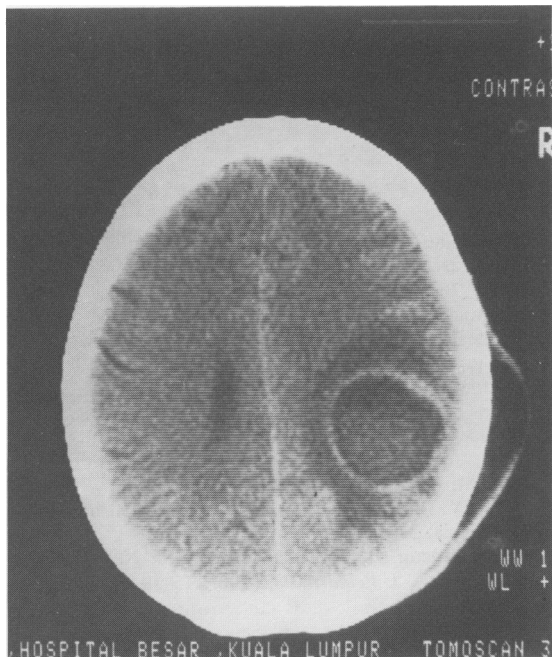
A CT scan showing a large right parietal intracerebral abscess with typical ring enhancement and fluid collection under the scalp.
